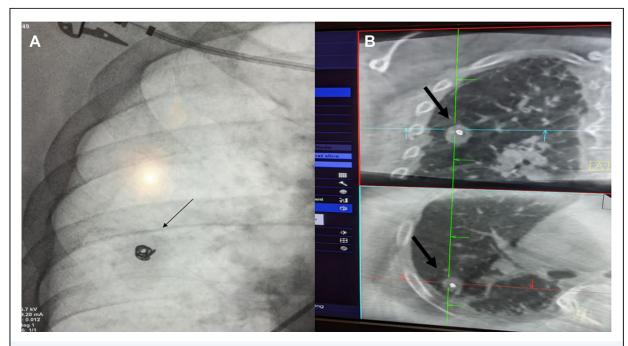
(A) Fluoroscopy image showing the fiducial placed in the right upper lobe solid nodule (arrow). (B) Cross-sectional cone beam images with fiducial placed within the right upper lobe solid nodule (arrow).
